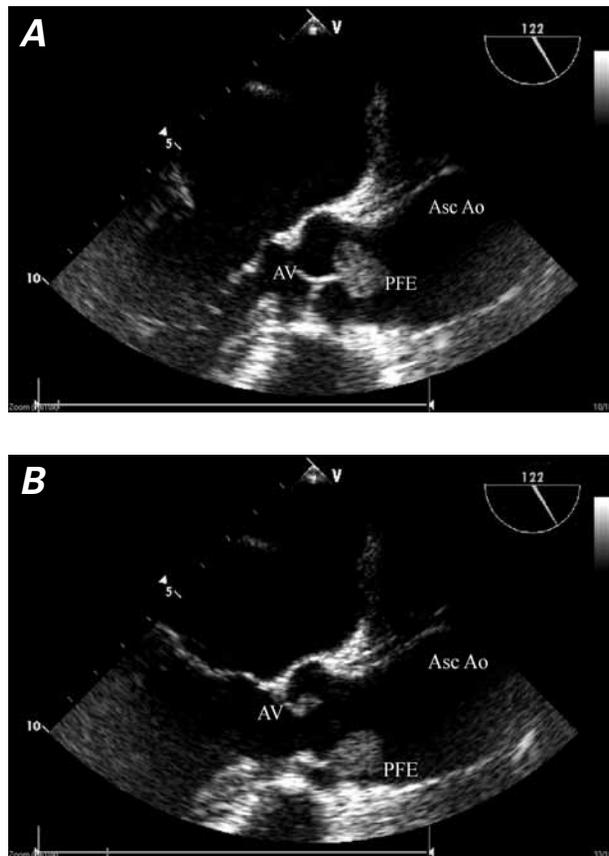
Preoperative transesophageal echocardiograms (mid-esophageal long-axis views) show the mass on the aortic valve during A) diastole and B) systole.
